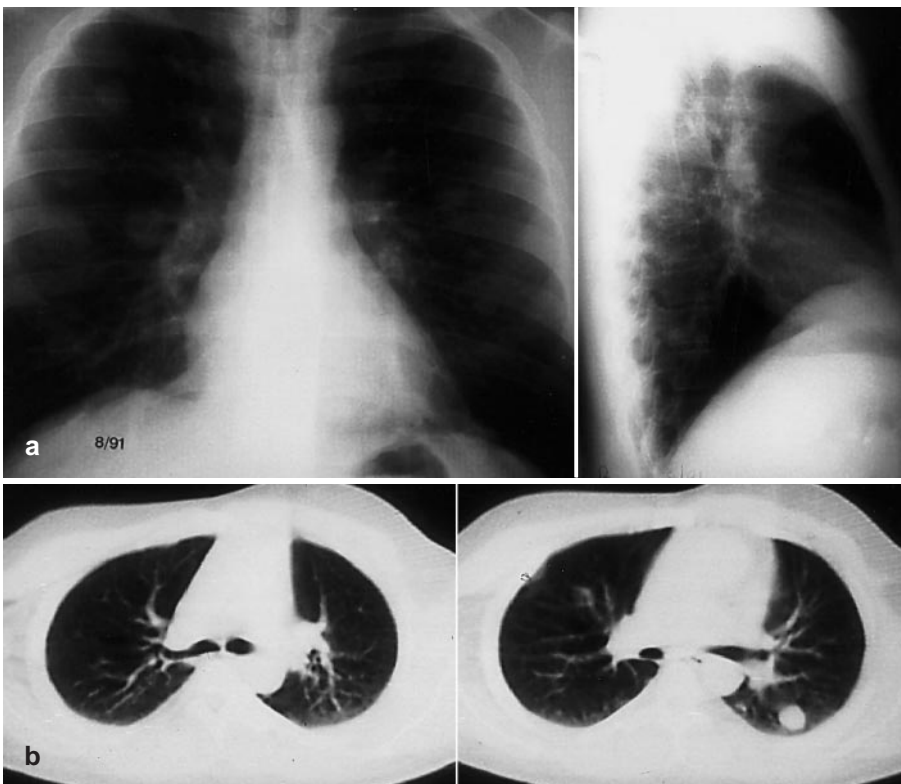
Case 1.* a Chest radiographs and b CT scan 2 years after the first diagnosis of the lung metastases; their number and size have increased
